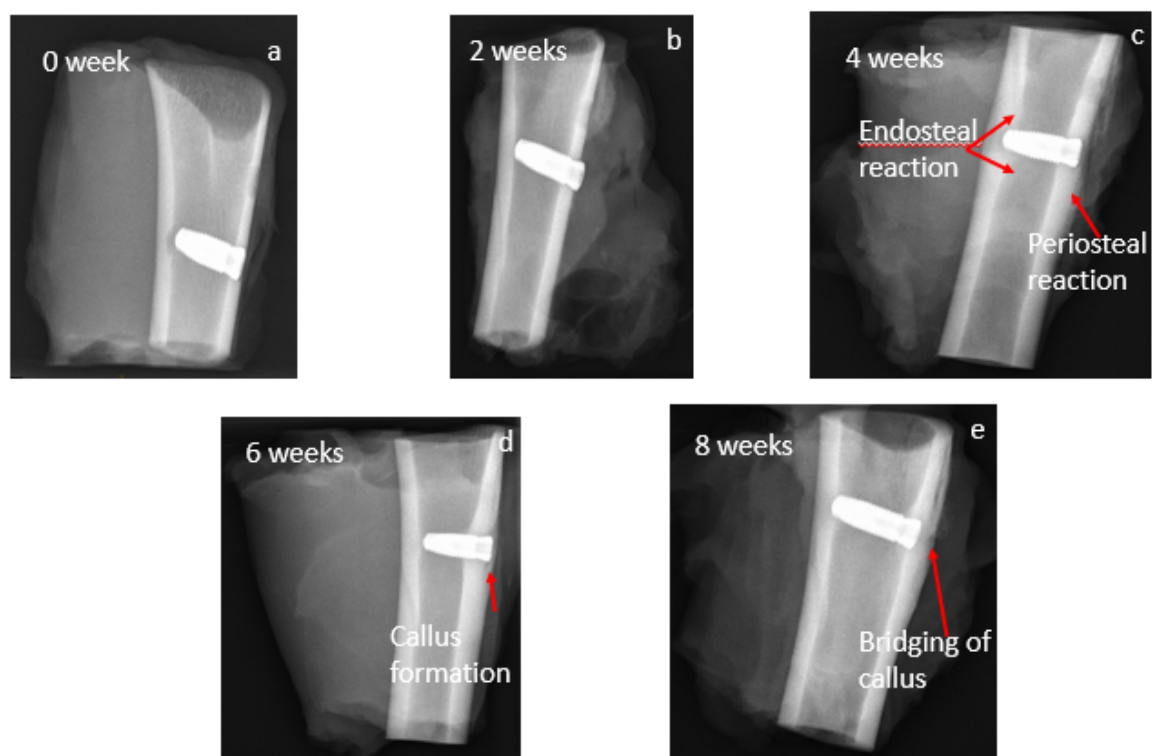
Progression of bone healing observed using x-ray radiographs.
